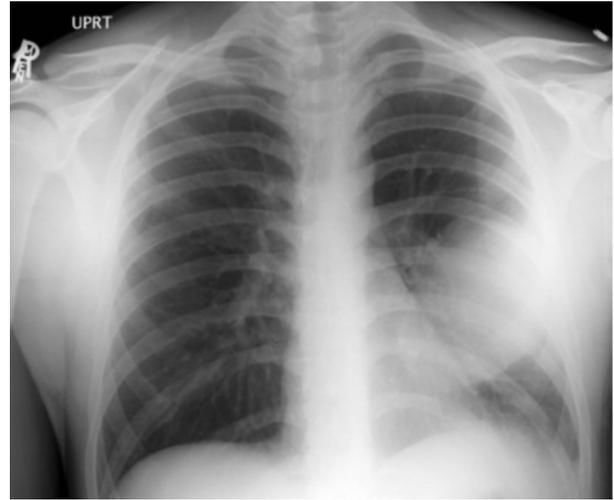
19-year-old man with primary synovial sarcoma of the lung. AP chest radiograph shows a large well circumscribed mass in the left mid lung and a small left pleural effusion.
